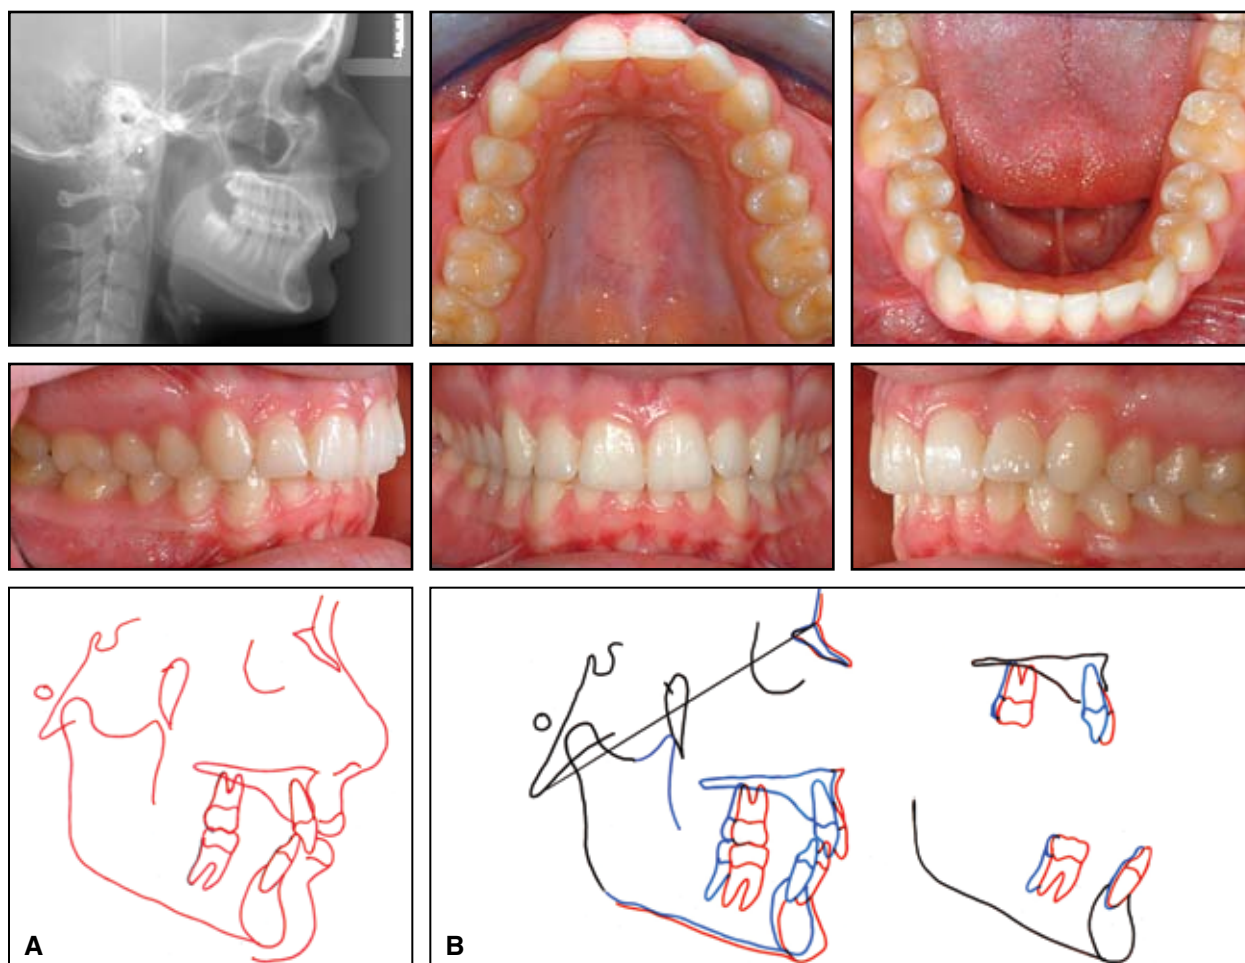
A. Case 3. Patient after 24 months of treatment. B. Superimposition of pre- and post-treatment cephalometric radiographs.
